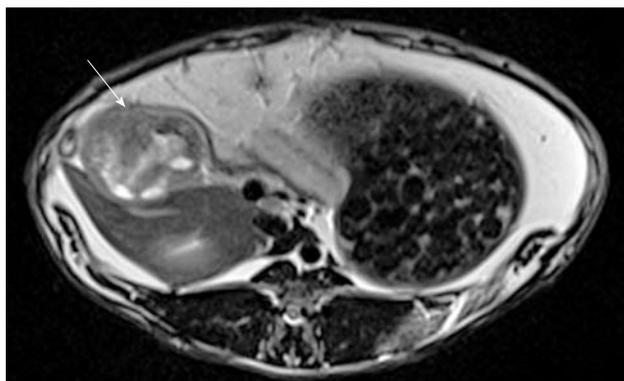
T2-weighted turbo spin echo magnetic resonance imaging showing pancreatic tumor (arrow) in axial view.
